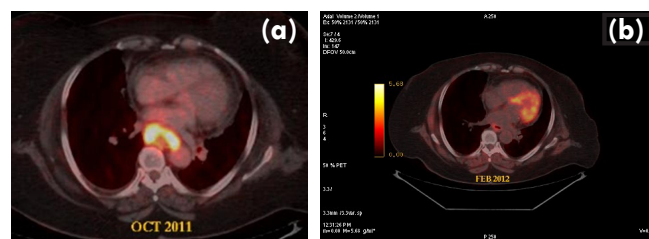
(a): Fused axial image showing esophageal wall thickening with increased FDG uptake. (before treatment). (b): Fused axial image, corresponding to figure 1A showing near complete metabolic resolution, with regression in wall thickening (after treatment).
